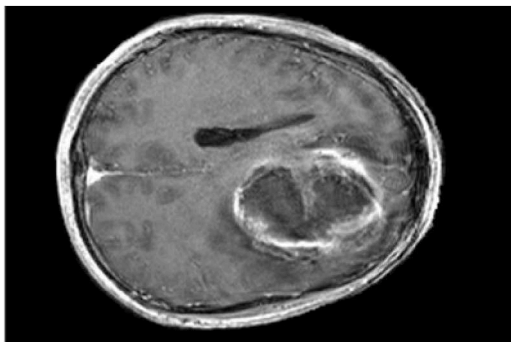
A transversal T1-weighted MRI experimental dataset of a brain presenting a GBM tumor.
